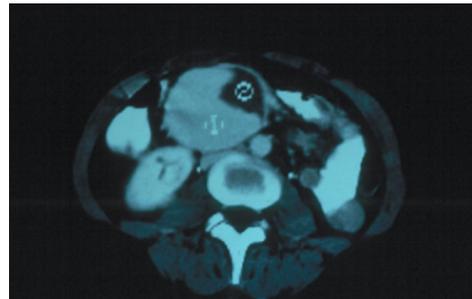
Computed tomography of the abdomen showing a large saccular aneurysm of the superior mesenteric artery, 6 x 7 cm in width and diameter.
